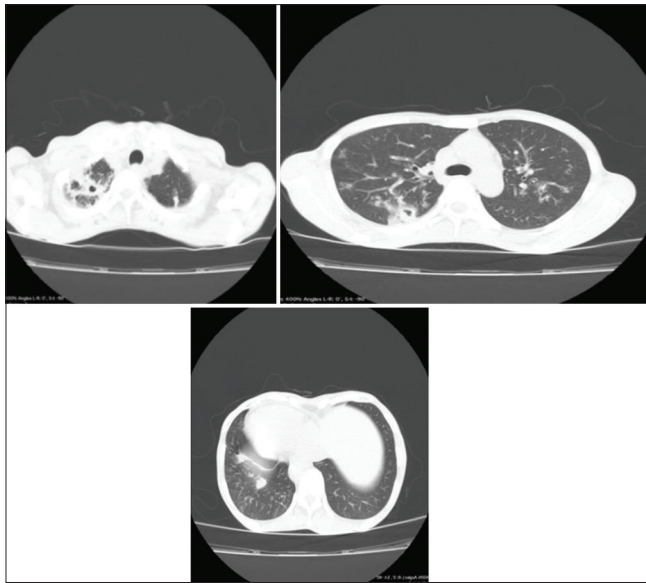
HRCT chest axial sections in a patient with drug-resistant tuberculosis showing multiple thick-walled cavities with centrilobular nodules arranged in branching pattern giving tree-in-bud appearance along with calcified granuloma
